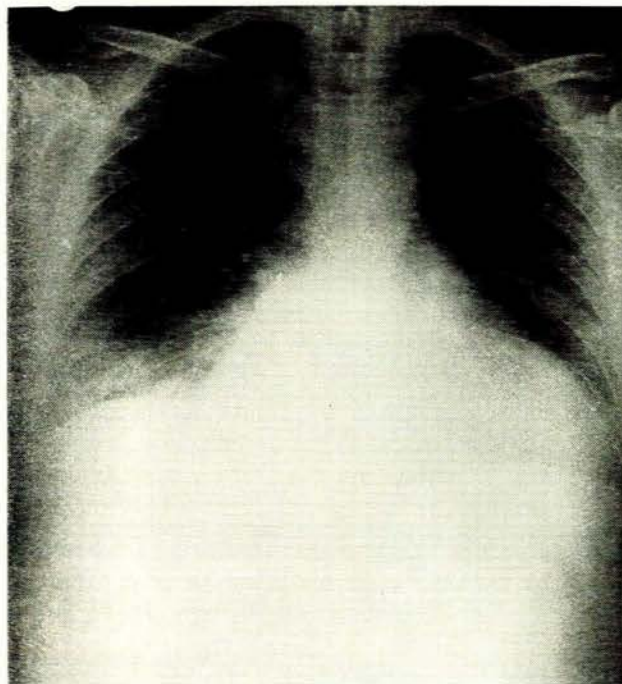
PA radiograph of chest, showing generalized cardiac enlargement and increased markings at right lung base.
